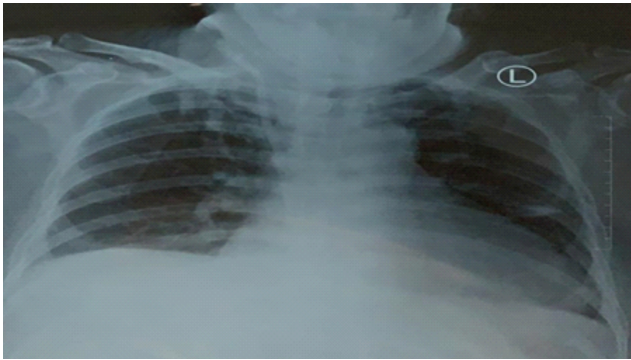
X-Ray showing cardiomegaly sign
